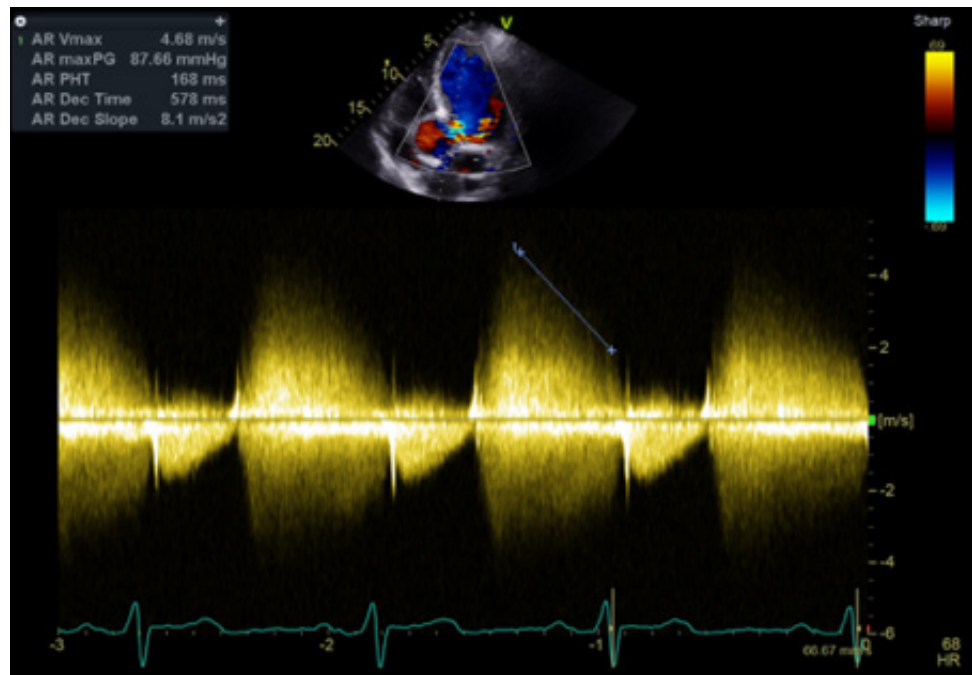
Echocardiogram demonstrating severe aortic regurgitation on Doppler assessment.
